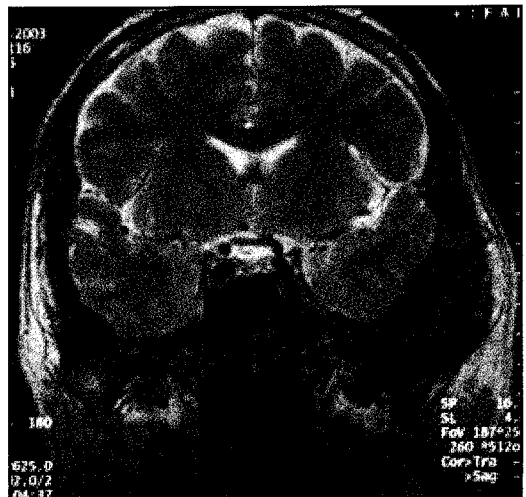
T2 weighted MRI showing intermediate signal intensity in the left temporal bone.
